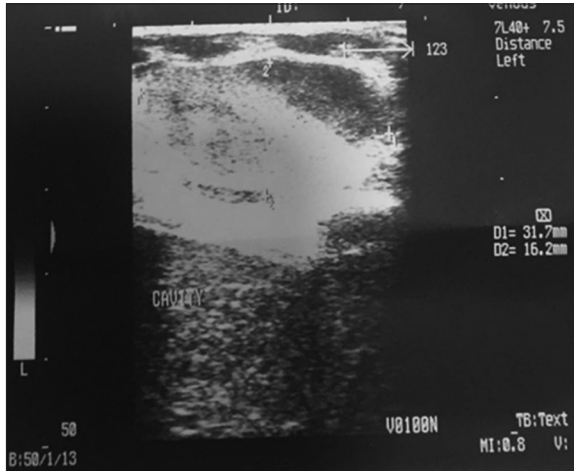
Soft-tissue swelling ultrasonography showing cyst at anterior chest wall
